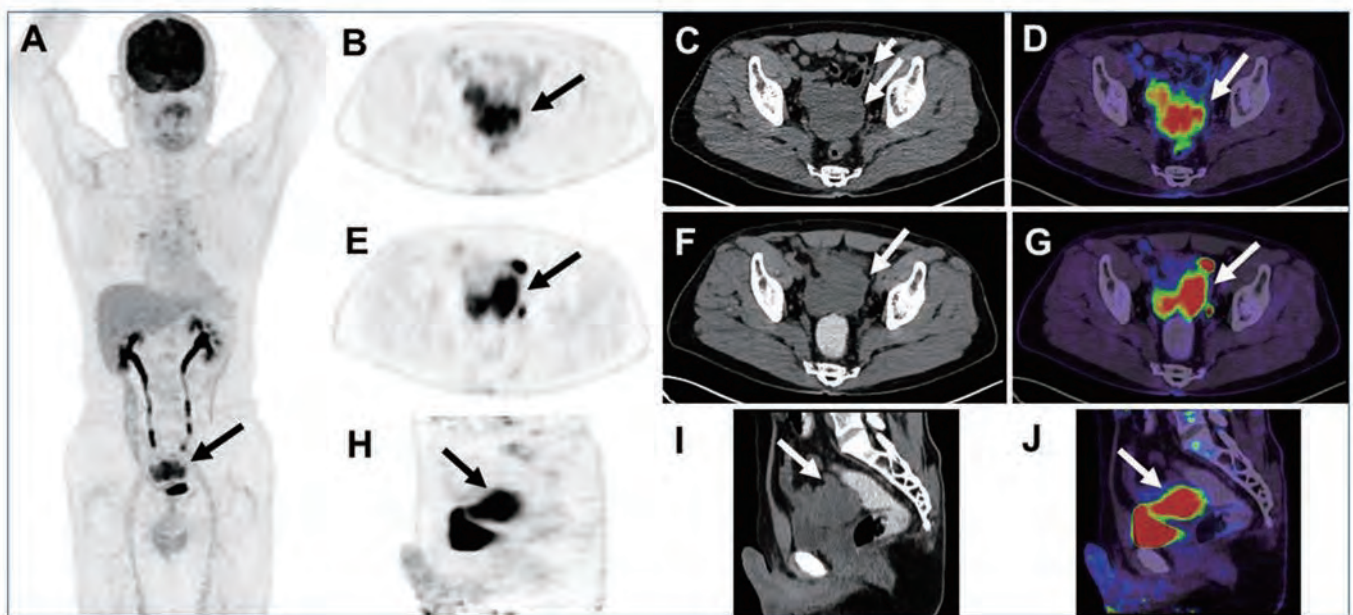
A 63-year-old man received FDG PET/CT for tumor survey. The arrow pointed to an irregular mass (7.5 cm, maxSUV: 12.3) with heterogeneous intense FDG uptake in the pelvic cavity (A, MIP images of PET; B, Transverse PET; C, Transverse CT; D, Transverse PET/CT fusion) with suspicious small intestine involvement (B, short arrow). Delayed FDG PET/CT scans (E, Transverse PET; F, Transverse CT; G, Transverse PET/CT fusion; H, Sagittal PET; I, Sagittal CT; J, Sagittal PET/CT fusion) obtained after anal administration of laxative-augmented contrast medium showed the lesion (arrow) was not in rectosigmoid lumen.
